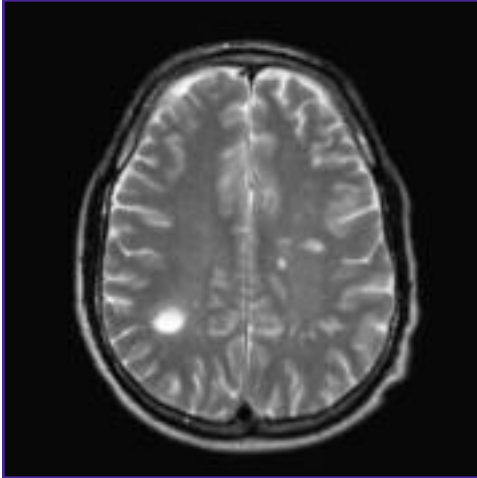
MRI brain showing multiple T2 weighted white matter, hyperintense, signal abnormalities.
